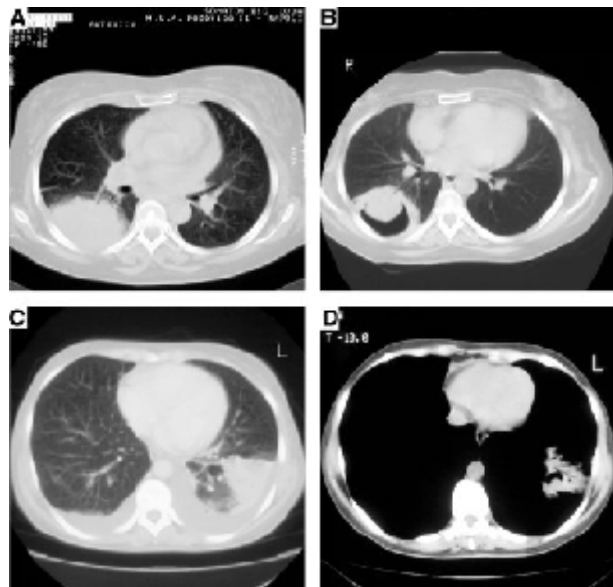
Changing characteristics of invasive pulmonary aspergillosis on computed tomography scans. (A) Subpleural large parenchymal masses with a surrounding halo of ground-glass attenuation (halo sign), in the right lung; a small nodular lesion in the left lung. (B) Two weeks later, a fungus ball inside the right lesion. (C) Large triangular infiltrate in the left lung, and bilateral pleural effusion. (D) Two weeks later, cavitation described as the air-crescent sign inside the parenchymal lesion.
